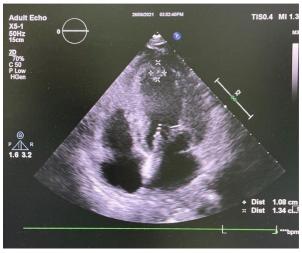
Echocardiography showing LV apical thrombus
